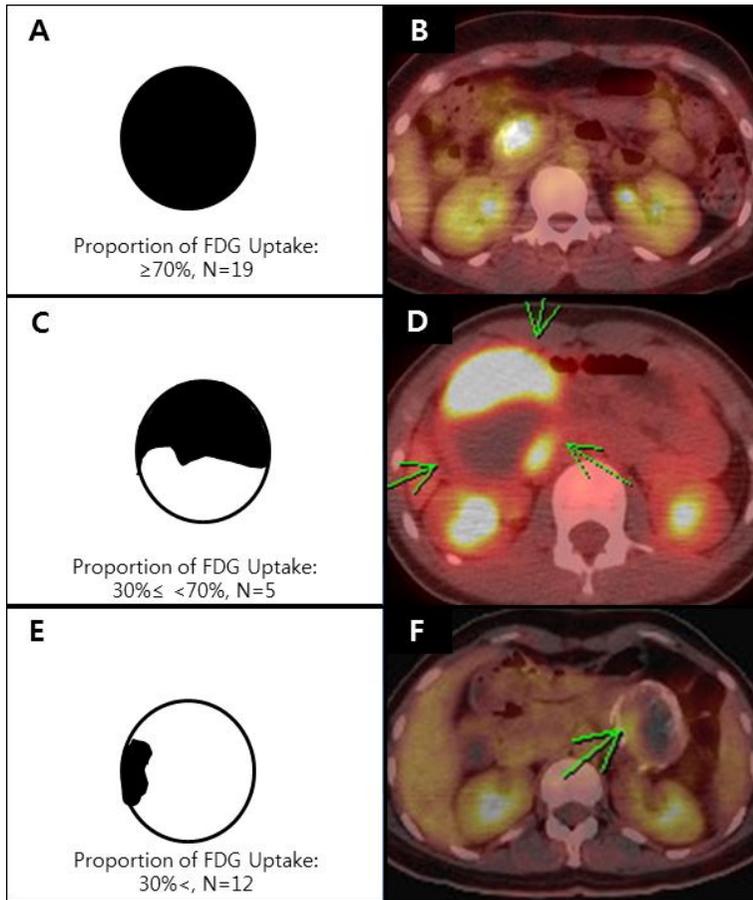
Clinical patterns of ^{18}F FDG-uptake in SPT of the pancreas.
